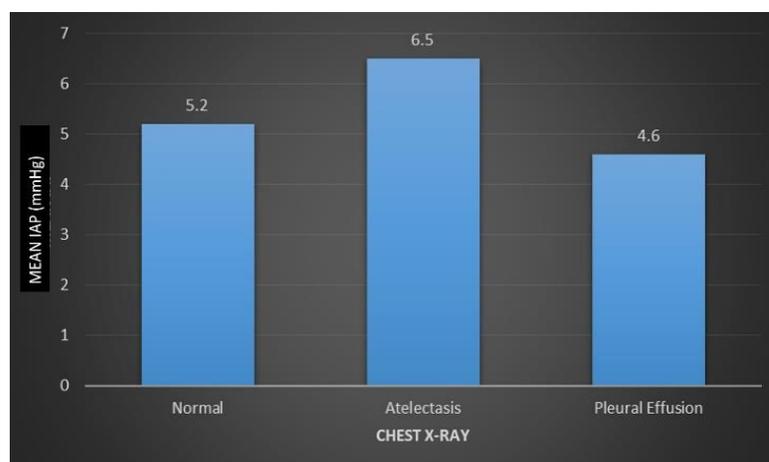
Mean IAP of patients with respect to chest X-ray findings
